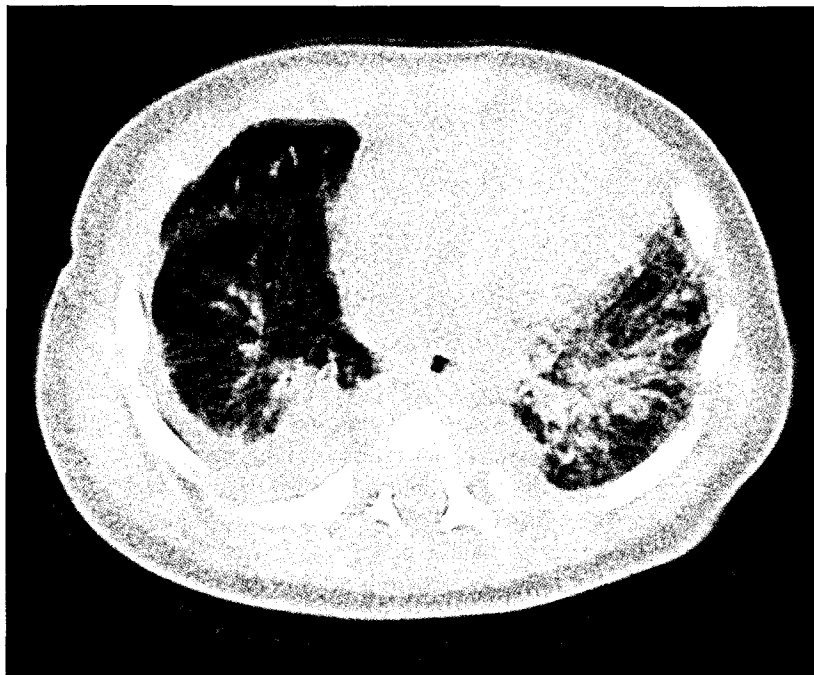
Case 1. High-resolution computed tomography shows diffuse thickening of the interstitium, both peribronchovascular and within the septa surrounding the lobules.
